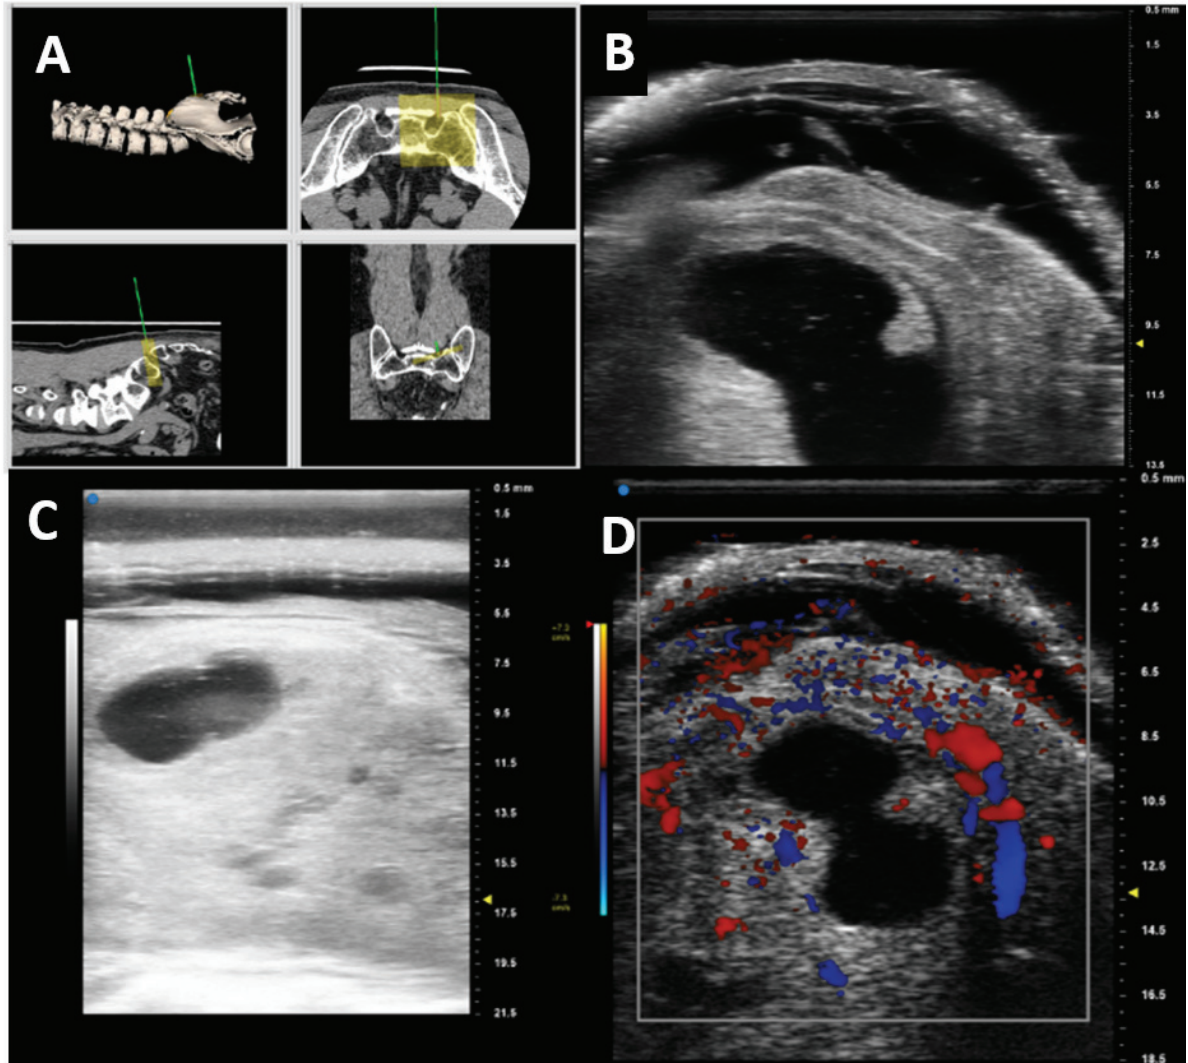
Patient 2: Tracked axial and longitudinal intraoperative high frequency  $\mu$ US images acquired at 30 MHz. A) Tracking information – field of view (Yellow Box) and trajectory (Green Line) of the ultrasound probe as tracked by the navigation system. B,C) Representative axial and longitudinal  $\mu$ US images. D) Intraoperative Doppler imaging for vessel delineation.
